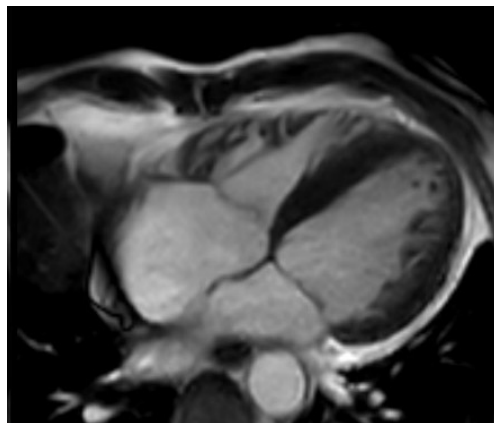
Cardiac magnetic resonance imaging of noncompaction cardiomyopathy - Four chamber view.
